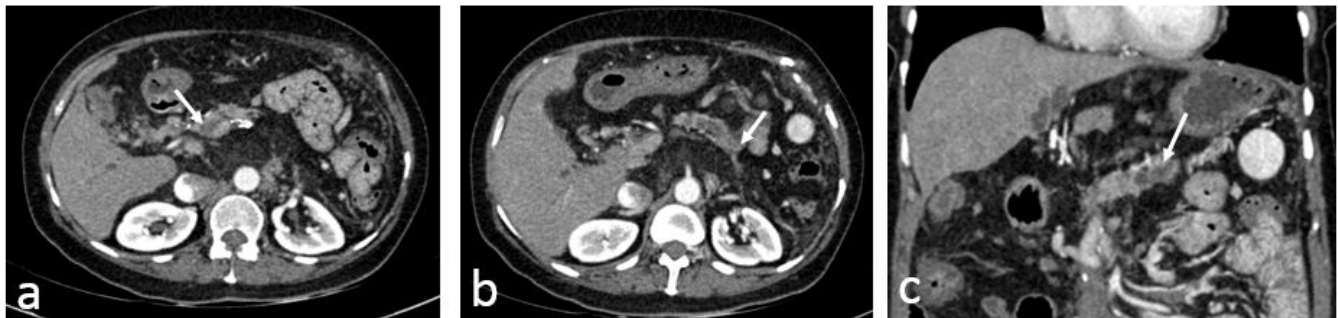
Contrast enhanced CT in axial (a,b) and coronal plane (c) in a patient with chronic pancreatitis show that the pancreatic parenchyma is atrophied and MPD is dilated (arrow). In this patient the calcifications are conspicuously absent.
